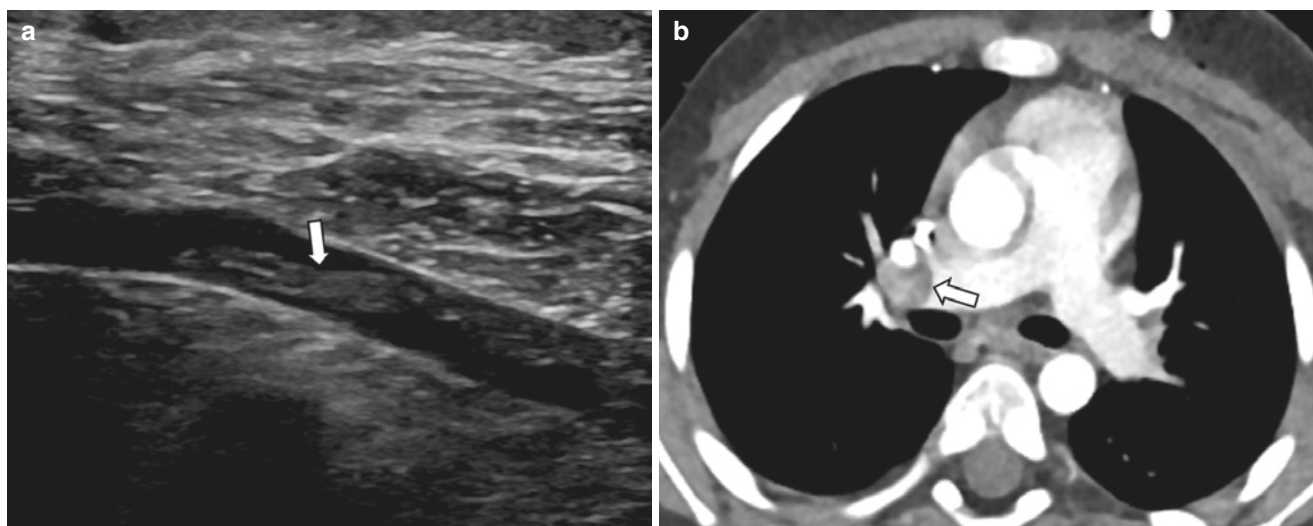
A 4-year-old boy with leukemia with left upper extremity PICC presenting with tachycardia and shortness of breath. (a) Sagittal gray-scale image from a left upper extremity Doppler venous ultrasound demonstrates linear echogenic material (arrow) within an
